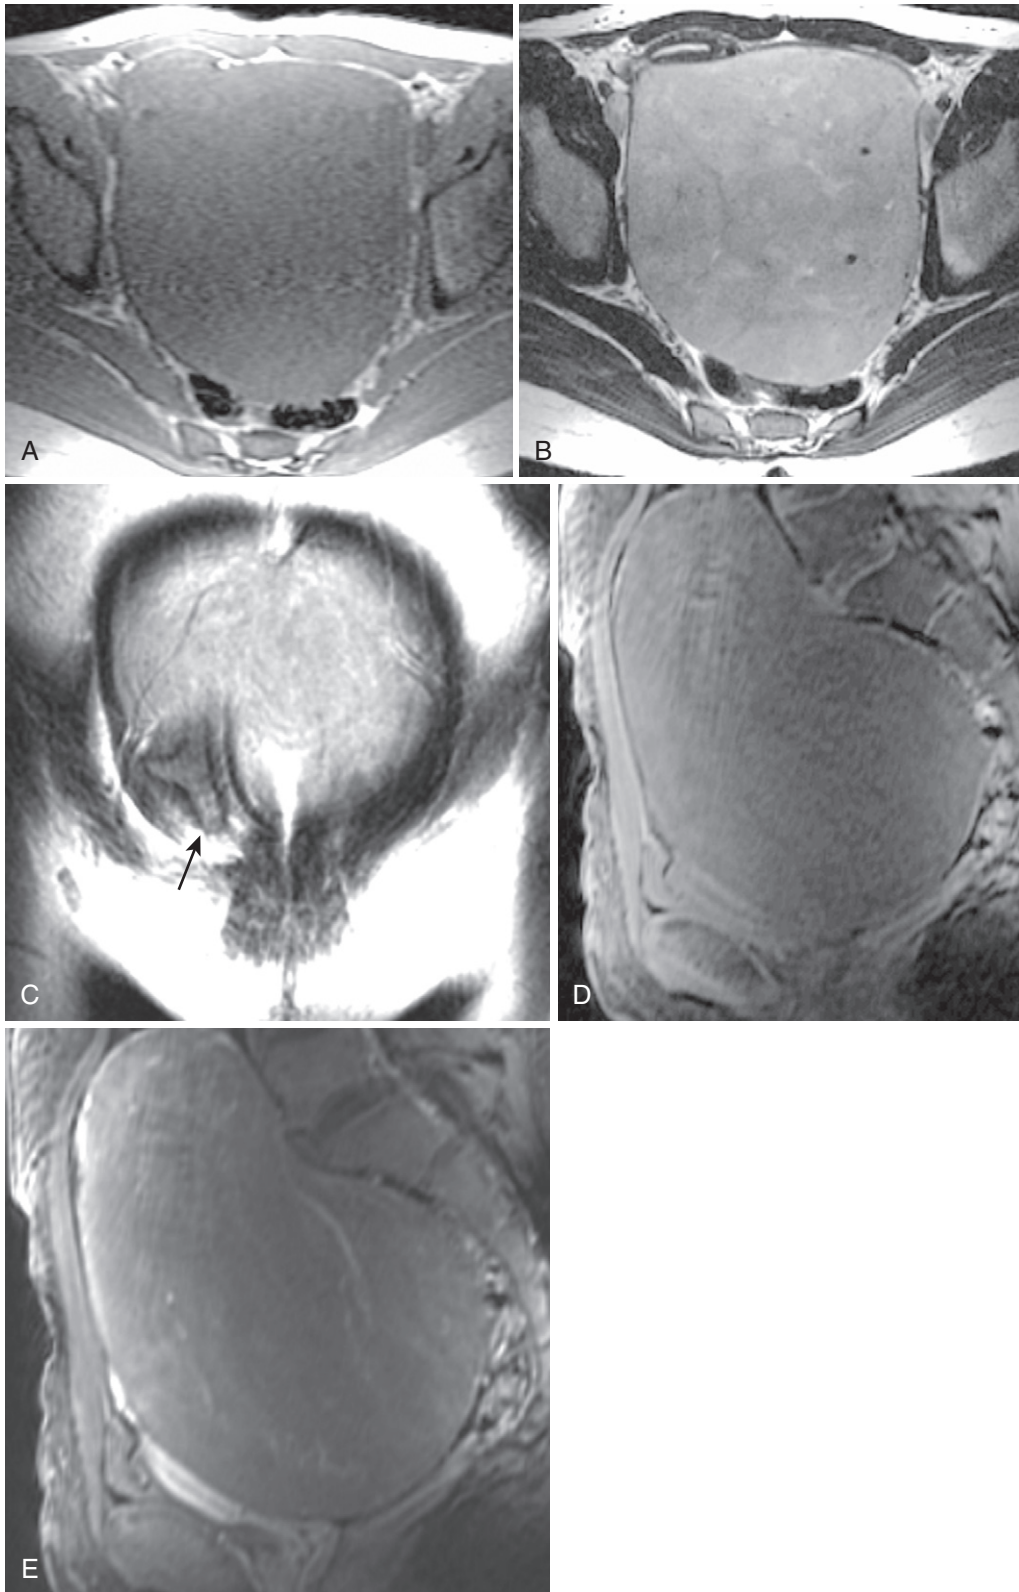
Dysgerminoma. Axial gradient echo T1-weighted in-phase (A) and axial (B) and coronal (C) T2-weighted images. A non-specific monotonous solid mass exerts marked mass effect on surrounding structures of the pelvis (note the uterus ventrally flattened against the abdominal wall—*arrow* in C). Precontrast (D) and postcontrast (E) images show diffuse enhancement.
